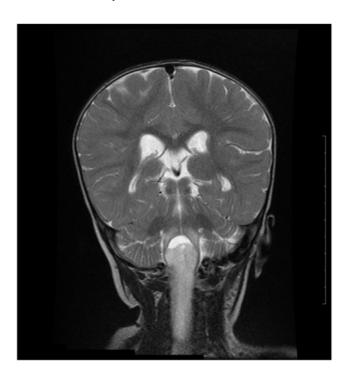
T2 Coronal MRI Cervical spine showing cervical cord intramedullary lesion extending from cervicomedullary junction down to c7 vertebral level
